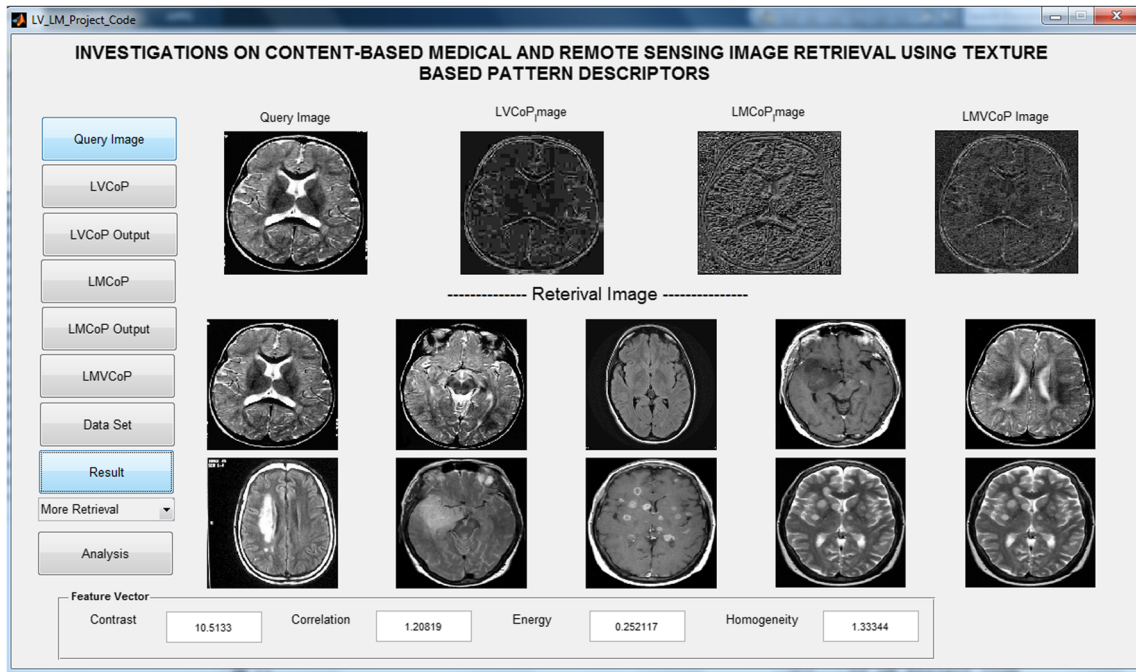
The main GUI of proposed LMVCoP system showing the step-wise results and the first 10 retrieved MRI brain images
